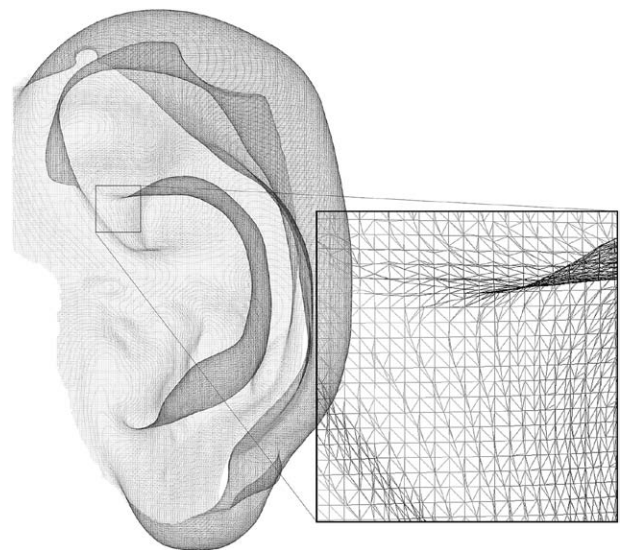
Mesh model based on CT scan. The surface of the original model is represented by small connecting triangles (faces), which all have their own surface areas. Accumulation of these areas provides an accurate measurement of the total surface area of the model.
